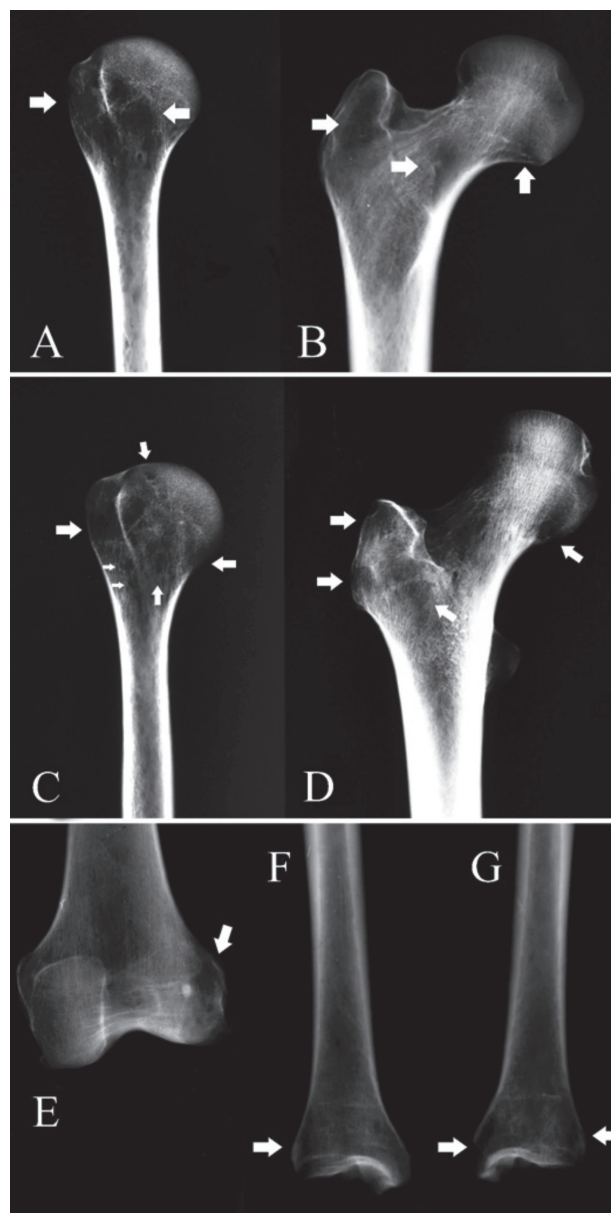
X-ray of the right proximal humerus (A) and right proximal femur (B) of Maria Afán de Ribera y Moura, duchess of Montalto (ca. 1615-1639). X-ray of the right proximal humerus (C), right proximal femur (D), left distal femur (E) and distal tibiae (F-G) of Catalina Moncada de Castro (1611-1659). The arrows indicate osteolytic lesions and areas of rarefaction without any reparative sclerotic borders.
